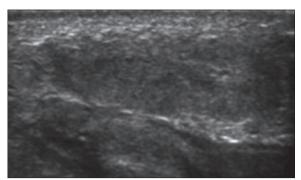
Ultrasound image of the left hemi-scrotum showing an oval iso-hypoechoic formation with a maximum diameter of 20 mm.
